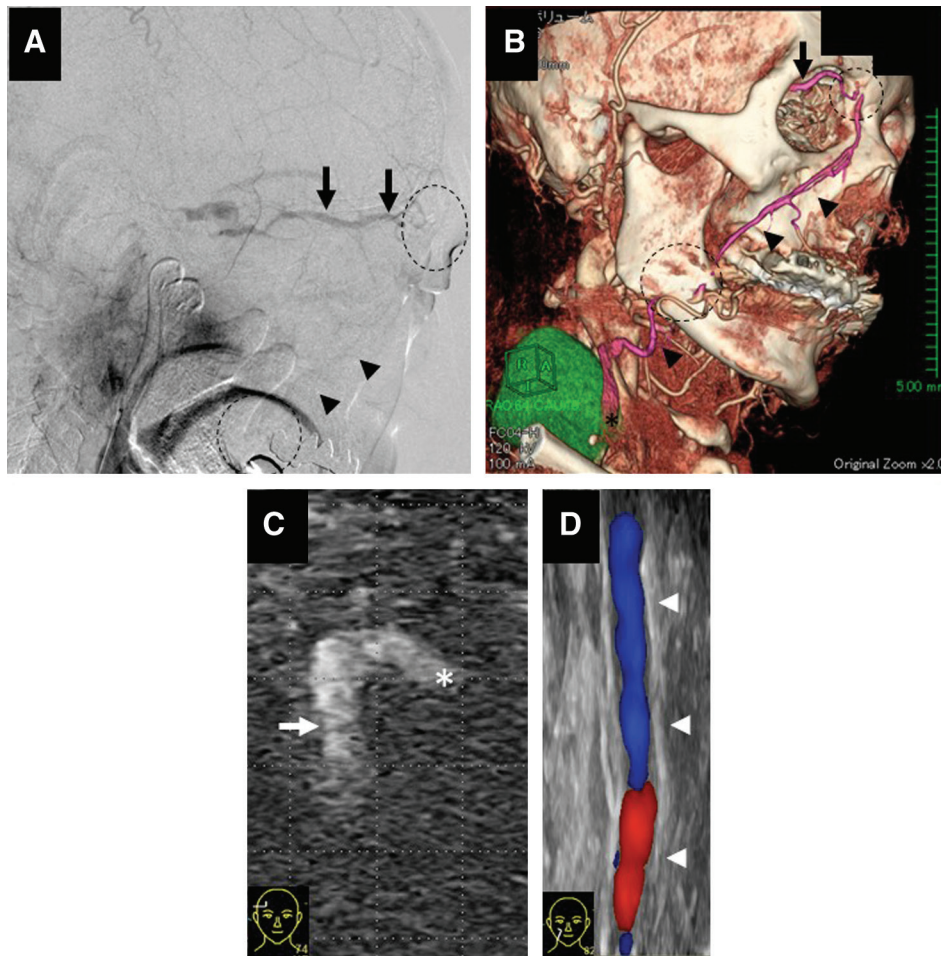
(A) Preoperative lateral view of the right external carotid angiogram showing a right-sided CS-DAVF with venous drainage from the SOV (arrows) into the FV (arrowheads) and the SPS. The bilateral IPSs were occluded. The drainage route between the SOV and the angular vein, and the mandibular section were unclear on DSA (dotted circles). (B) CTA showing the drainage route from the right SOV (arrow) to the right EJV (asterisk) through the FV (arrowheads). The drainage route between the SOV and the angular vein, and mandibular section were unclear on CTA (dotted circles). (C and D) The blood flow signals of the right SOV (arrow), the angular vein (asterisk), and the FV (arrowheads) were clearly observed on US but unclear on CTA. CS-DAVF: cavernous sinus dural arteriovenous fistula; CTA: computed tomography angiography; DSA: digital subtraction angiography; EJV: external jugular vein; FV: facial vein; IPSs: inferior petrosal sinuses; SOV: superior ophthalmic vein; SPS: superior petrosal sinus; US: ultrasonography
